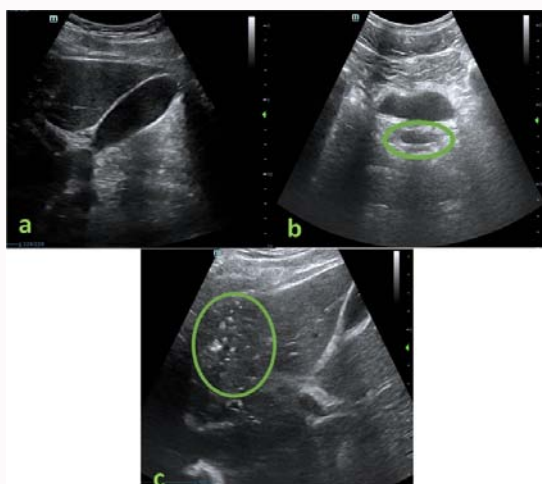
Salient ultrasound findings at admission. (A) Normal sized gall bladder without thickened or swollen walls, nor evidences of cholelithiasis. (B) Small fluid collection in Douglas' pouch (oval). (C) Focal, milliary hyperechoic enhancement of the left liver lobe consistent with pneumobilia (circle).
